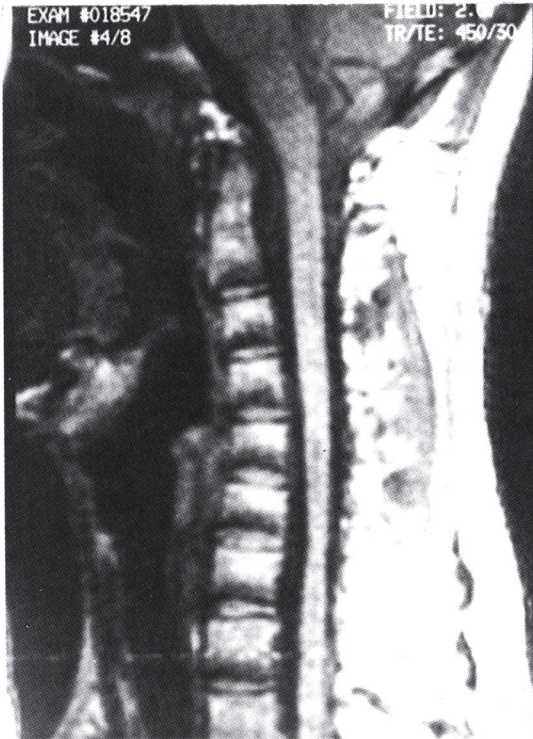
Sagittal T1-weighted MR image in a 20 year-old man with hand and forearm atrophy of 1 year's duration showing segmental atrophy in the lower cervical cord.
